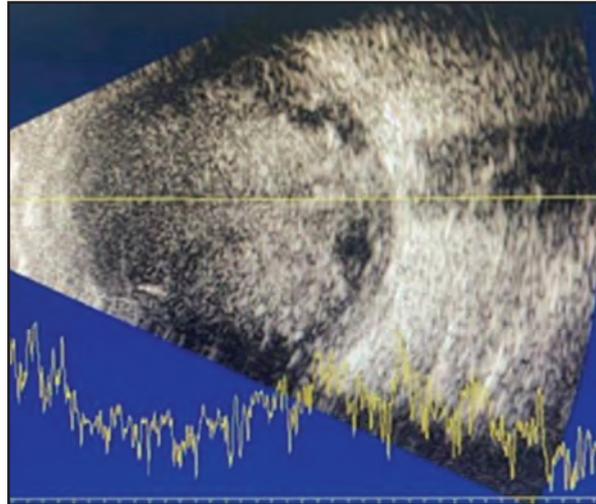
B-scan ultrasound of the right eye shows dense, diffuse vitreous haemorrhage with no evidence of a retrolenticular mass
